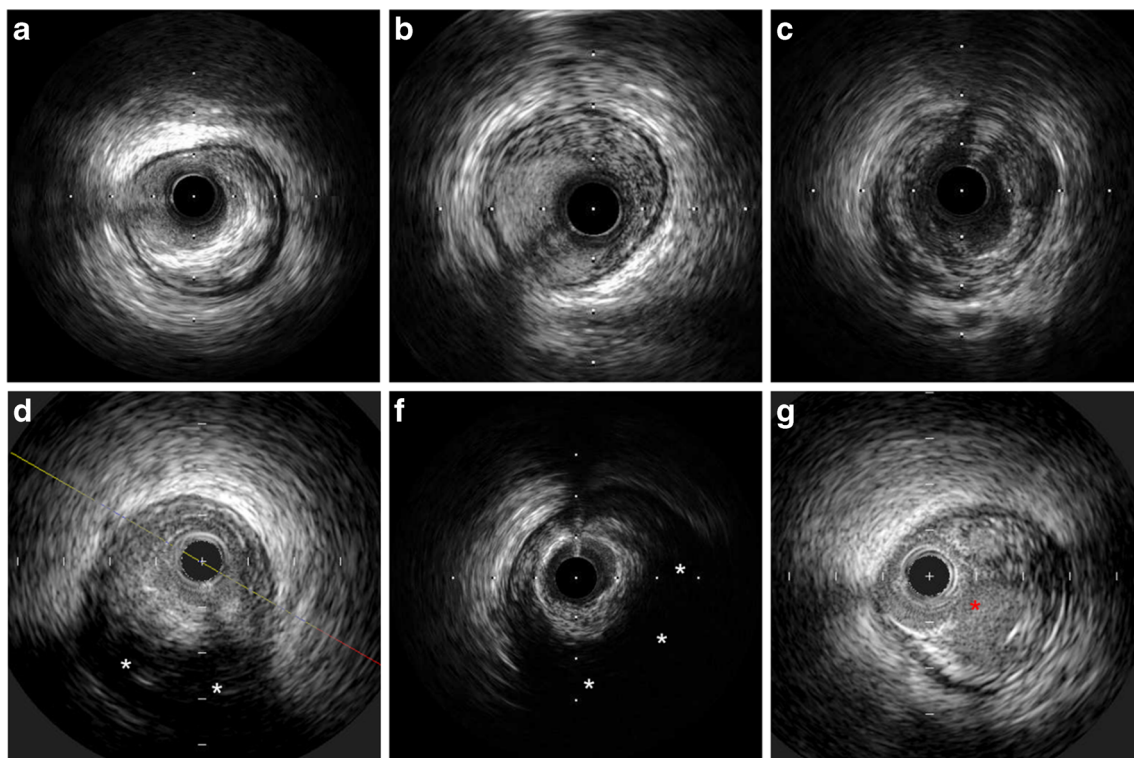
Intravascular ultrasound plaque characteristics. a Highly echogenic plaque. b, c Echolucent plaques. d–f Attenuated plaque (white asterisks). g Plaque rupture with ruptured cavity (red asterisk)
